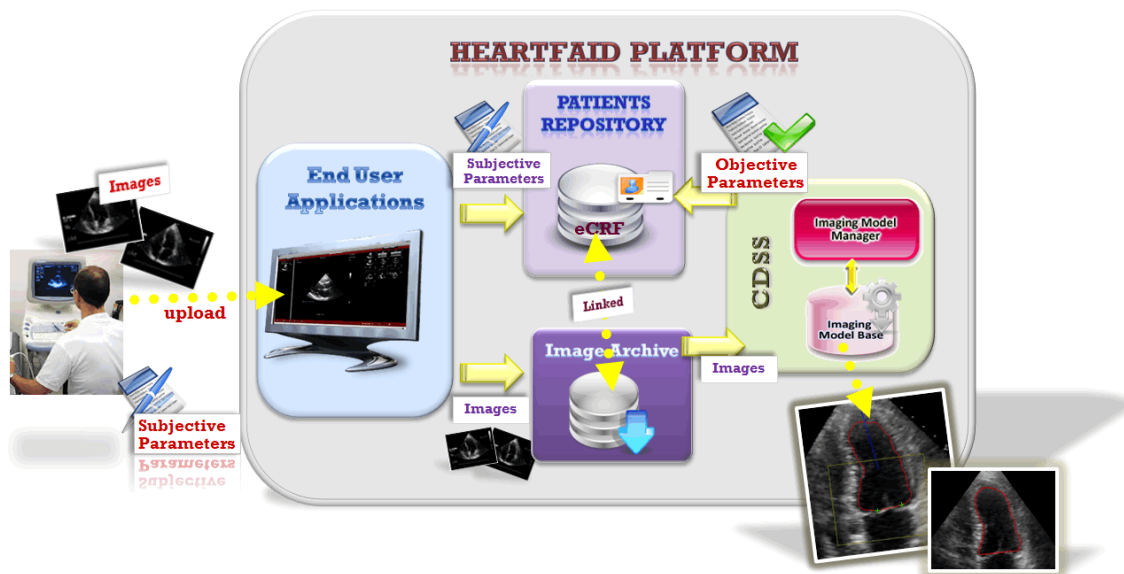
The process of echocardiographic image acquisition and processing
